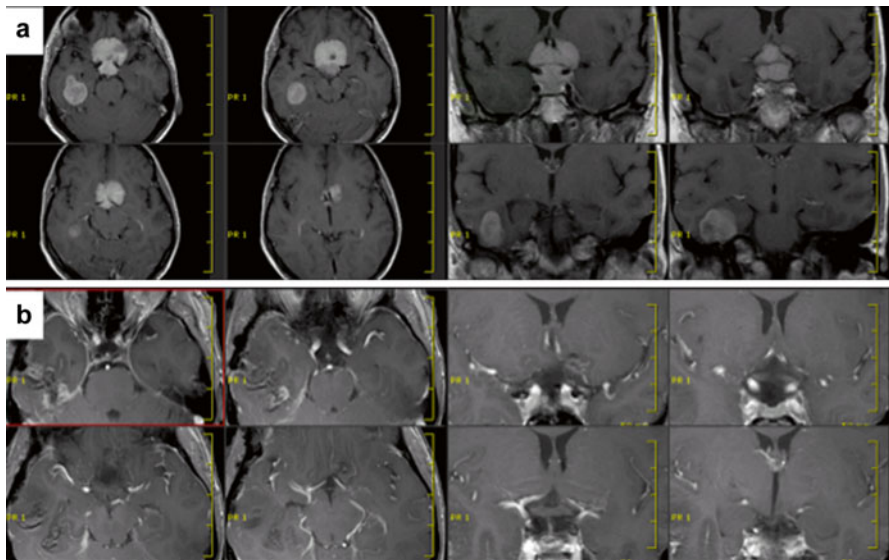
Progressive tuberculum sellae meningioma + right temporal meningioma removed in single frontotemporal approach. Patient finally decided to undergo surgery when visual problems became more evident – and they disappeared after surgery (a) preop MRI, (b) postop MRI the day after surgery, improved visual function
